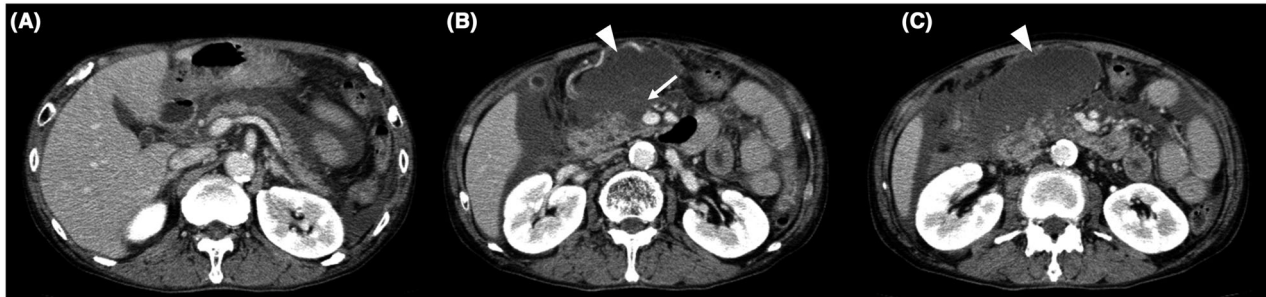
The initial CT scan reveals peripancreatic fluid collection A, OIS grade IV pancreatic injury with disruption of the pancreatic body, B, (arrow) and fluid collection in the lesser sac, B, C, (arrowheads). CT, computed tomography; OIS, Organ Injury Scale.
